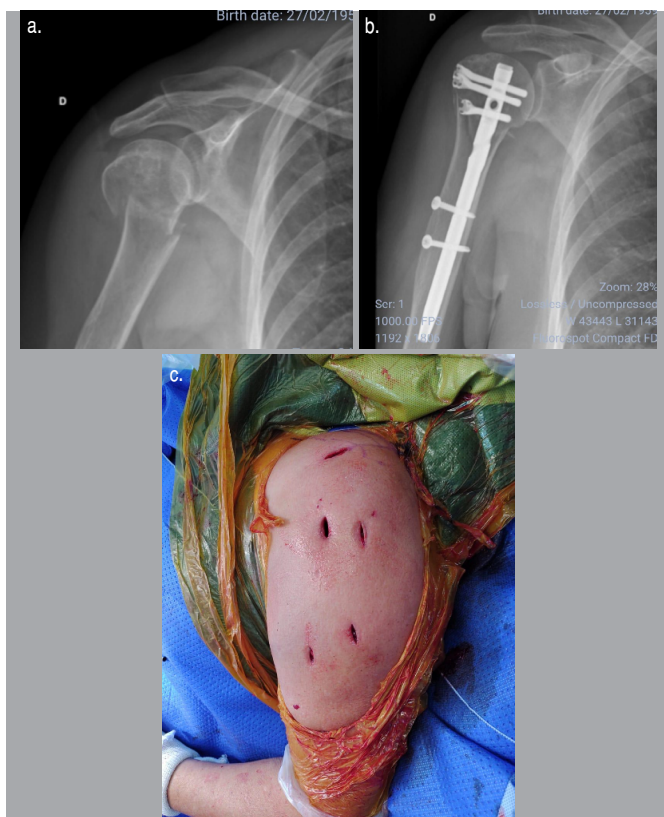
a. Fracture in two parts of the surgical neck; b. Postoperative radiography; c. Intraoperative appearance.
